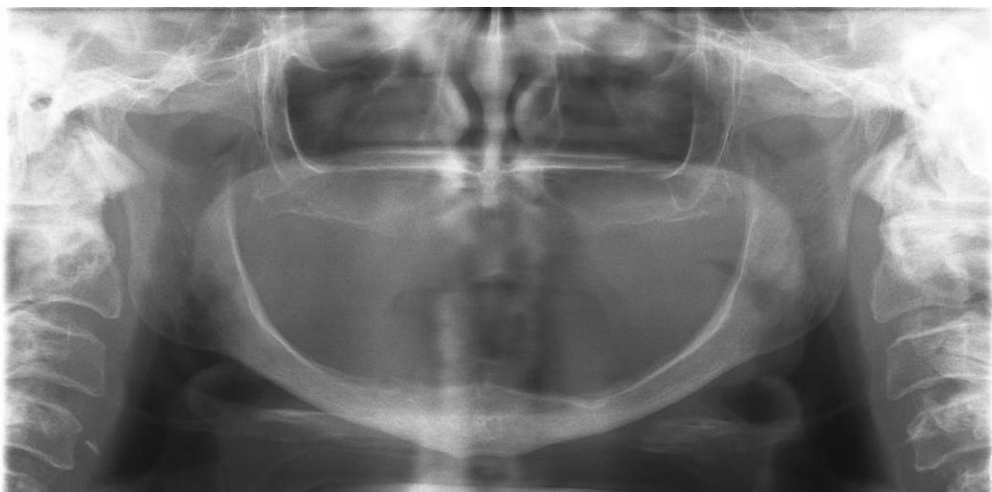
Preoperative OPG X-ray
